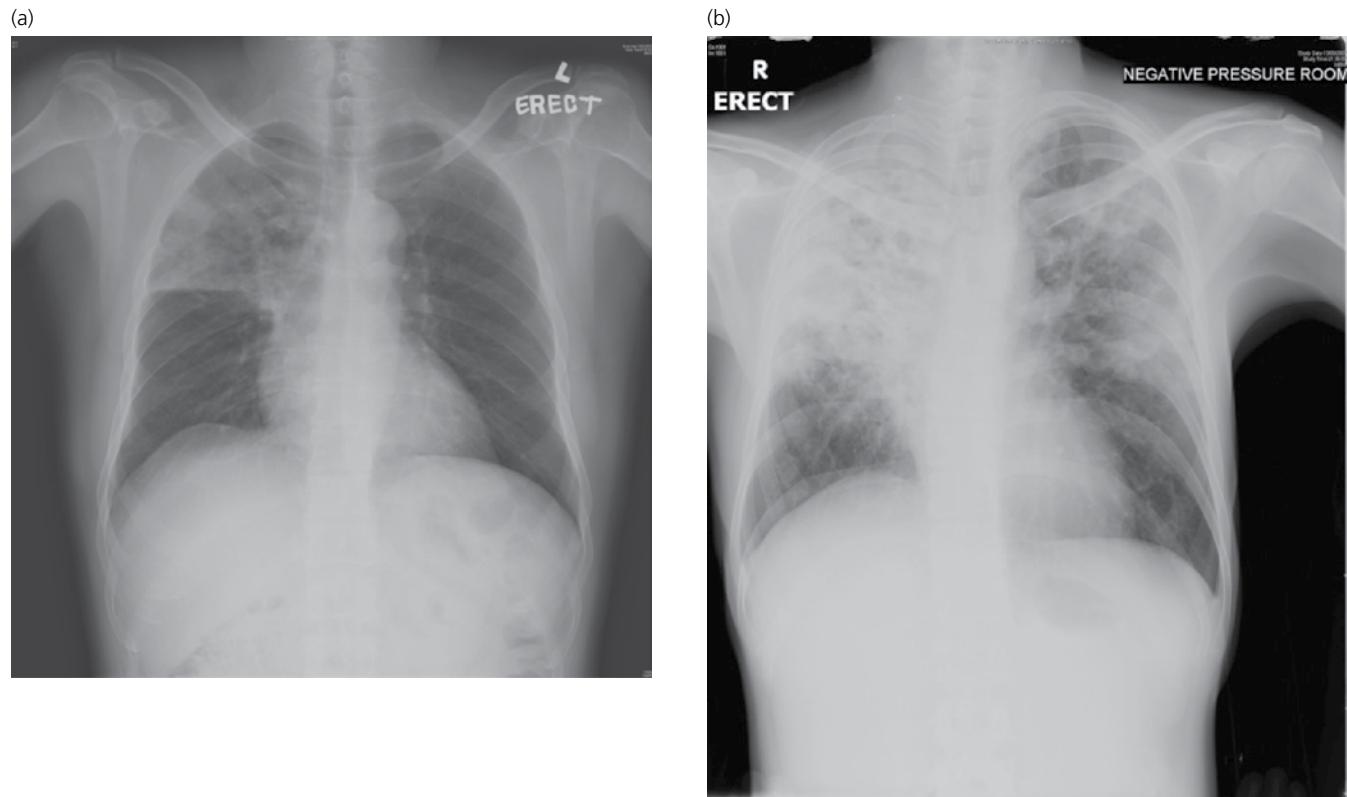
(a) A 49-year-old man with diabetes and obesity, not receiving regular follow-up, and presenting with haemoptysis and sputum smear positive for tuberculosis. Chest X-ray shows extensive right upper lobe pneumonic changes. (b) A 30-year-old man with diabetes but no regular follow-up presenting with a cough for four months with weight loss, and sputum smear positive for tuberculosis. Chest X-ray shows extensive bilateral and cavitatory disease.
